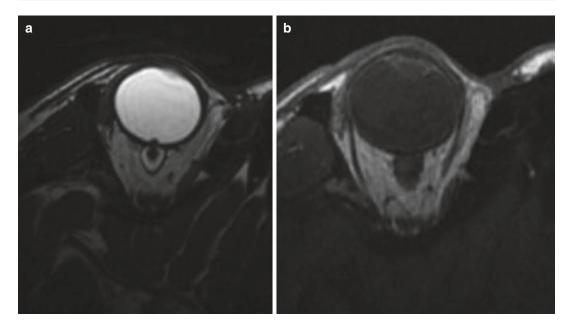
Surface coil MRI images of the right eye showing a small nodular lesion at the right optic disc. It is not appreciable in the T1 WI (b) and is hypointense in T2 WI (a)—Melanocytoma
